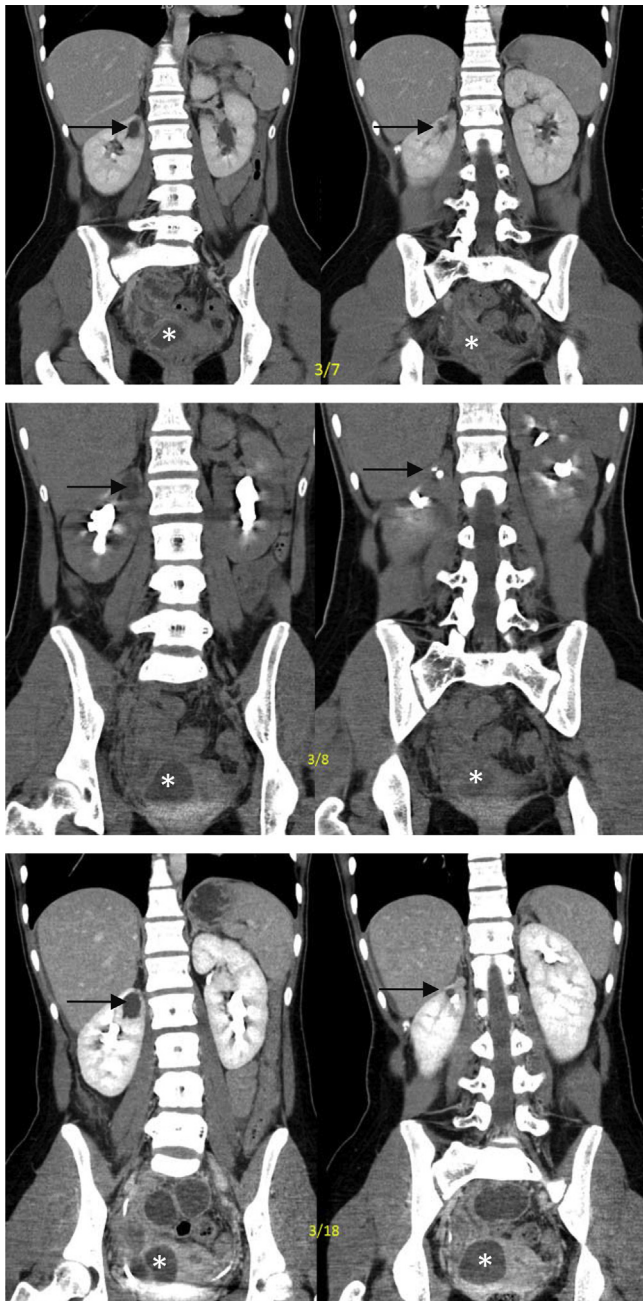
Serial computed tomography scans after first surgery showed renal duplications with visible renal parenchyma and upper ureters. The right upper moiety ureter was dilated (arrow) and localized abscess (*) was seen in the right pelvis.
